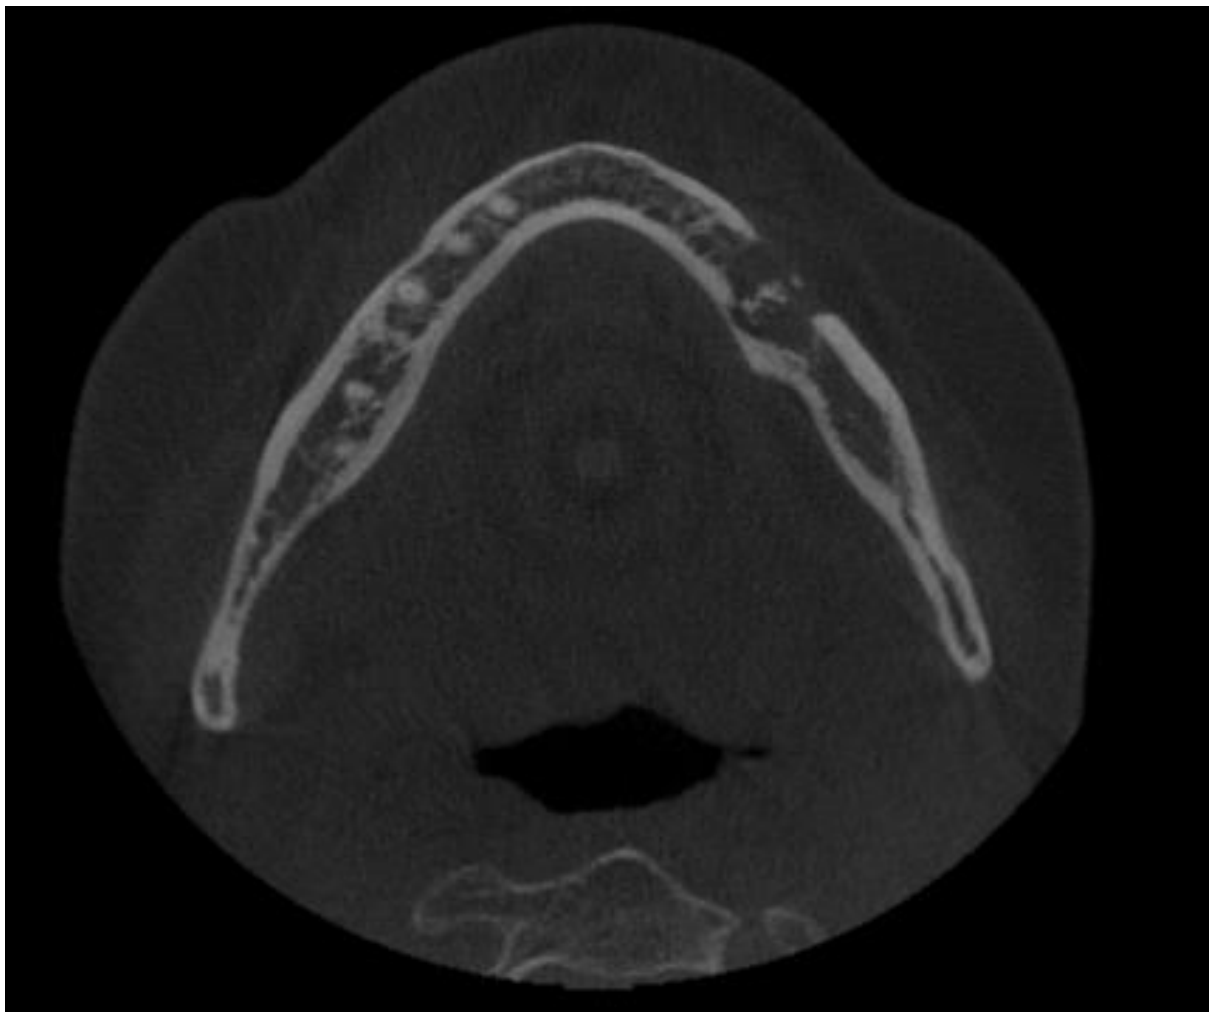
CBCT axial slice of left mandible schwannoma.
